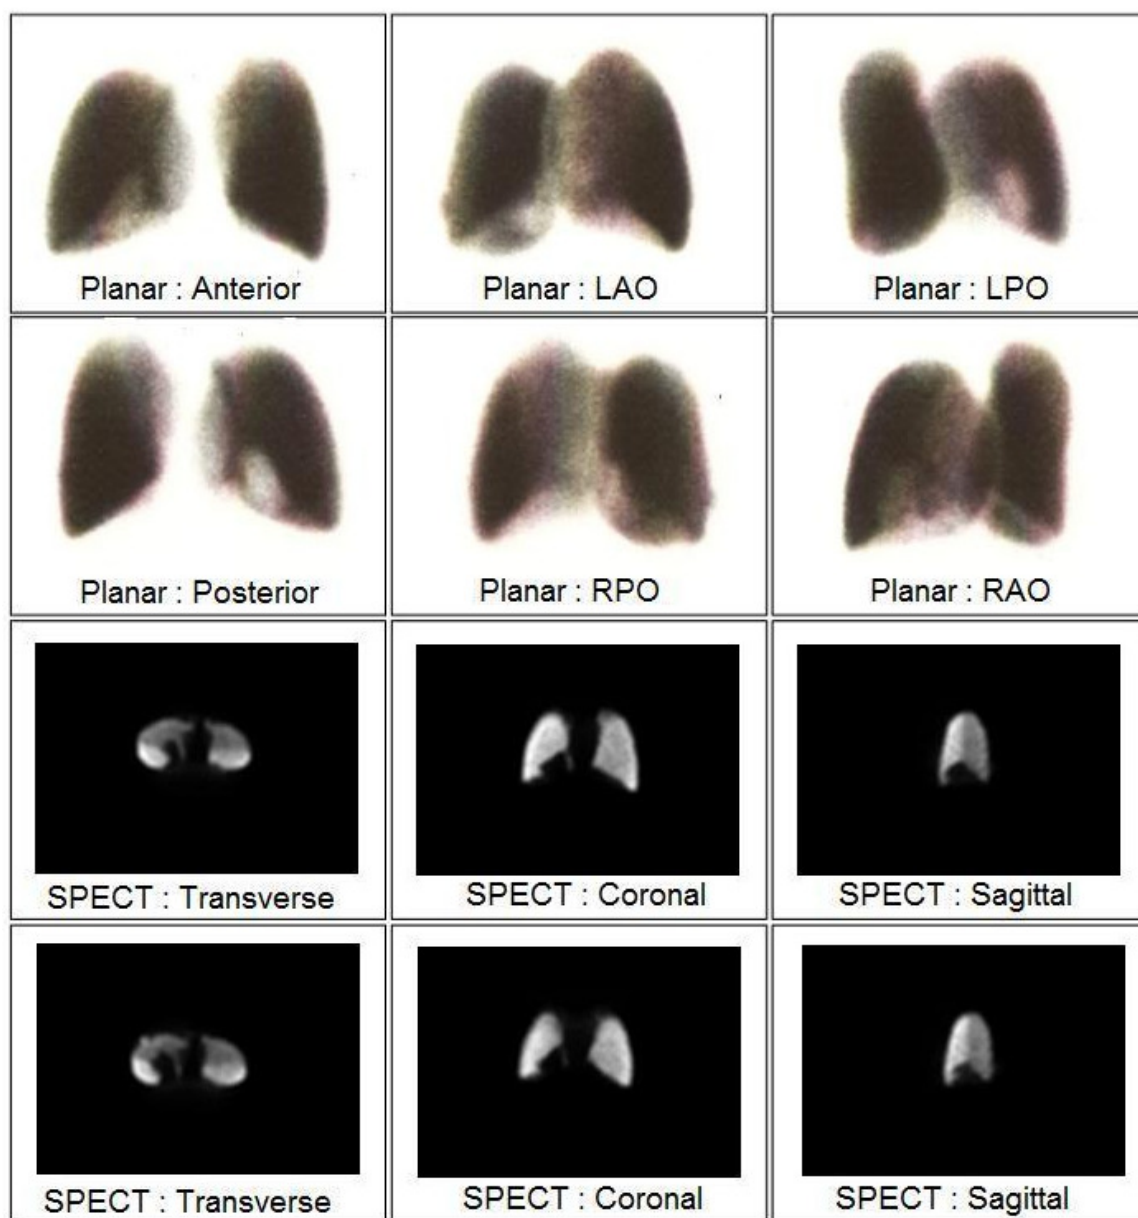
Planar and SPECT images of a perfusion defect within the medial basal segment of the right lower lobe.
